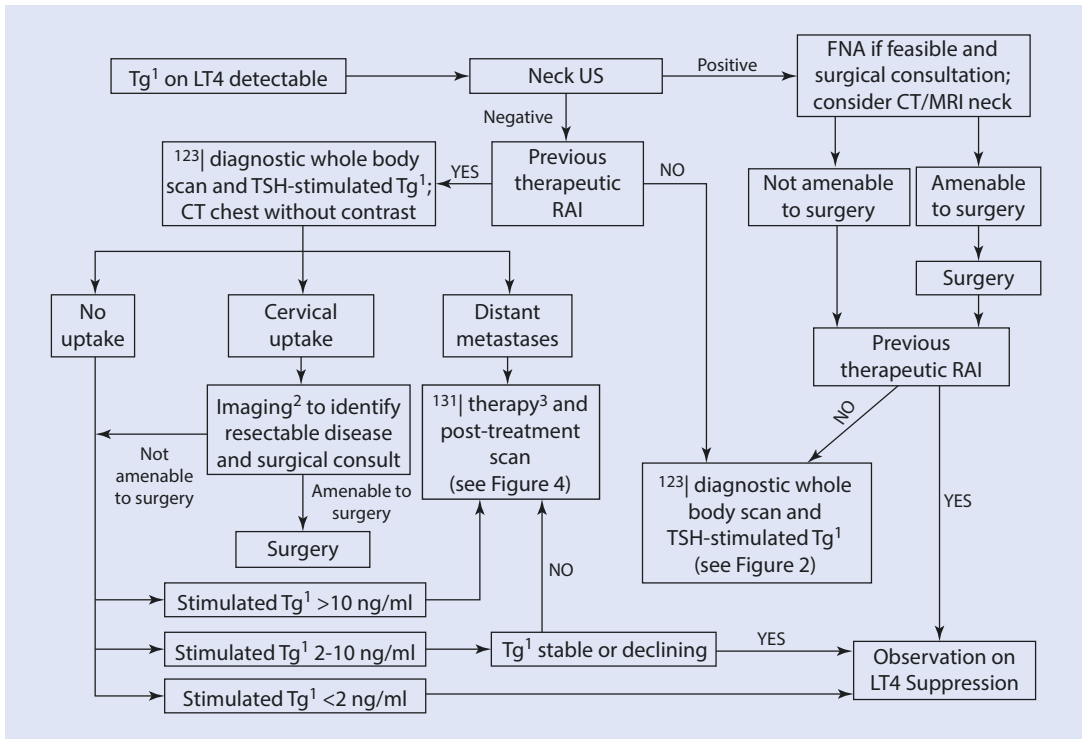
Postoperative staging for persistent disease and risk for recurrence. ¹Assumes a negative TgAb; in TgAb-positive patients, the presence of TgAb alone cannot be interpreted as a sign of disease unless the titer is clearly rising. ²Imaging includes SPECT/CT at the time of the diagnostic thyroid scan and/or contrast-enhanced
